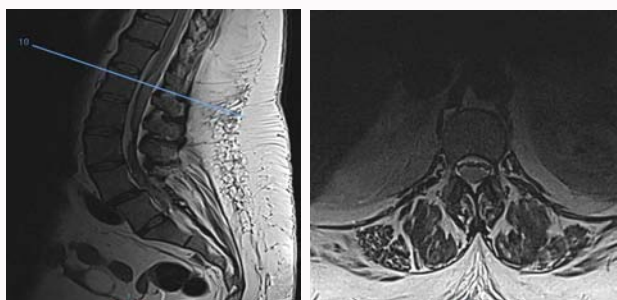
An MRI showing the SSDH.
